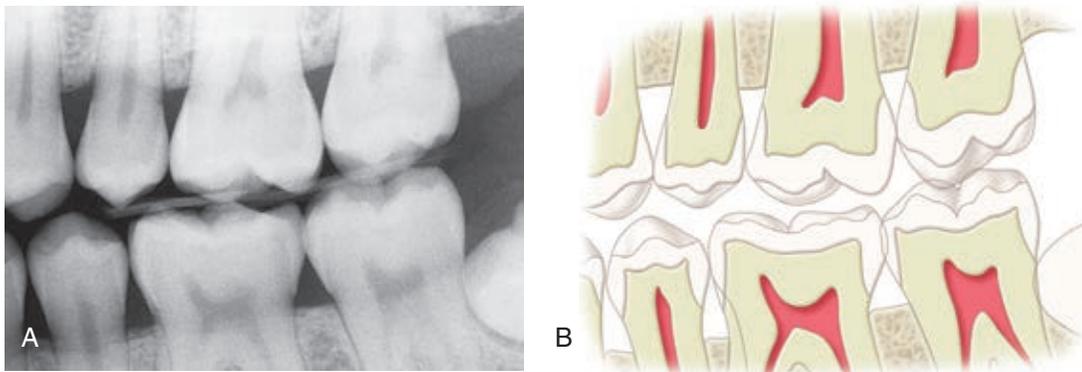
Bitewing radiograph of normal teeth, free from caries. Note the uniform density of the enamel on the interproximal surfaces. A third molar is impacted on the distal aspect of the lower second molar. The interproximal bone levels are uniform and located slightly below the cemento enamel junctions, suggesting a healthy periodontium.
